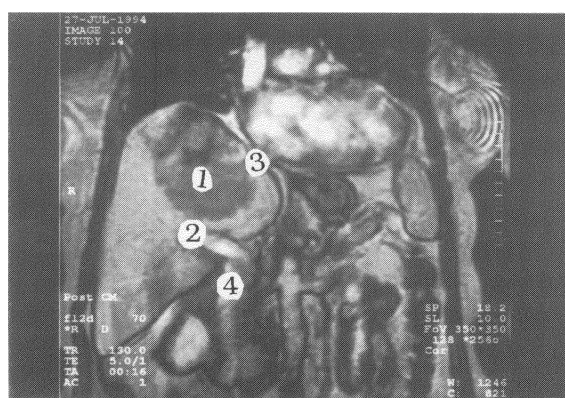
Magnetic resonance image of upper abdomen pre-operation (coronal plane). 1: tumour, 2: portal vein, 3: right hepatic vein, 4: inferior vena cava.
